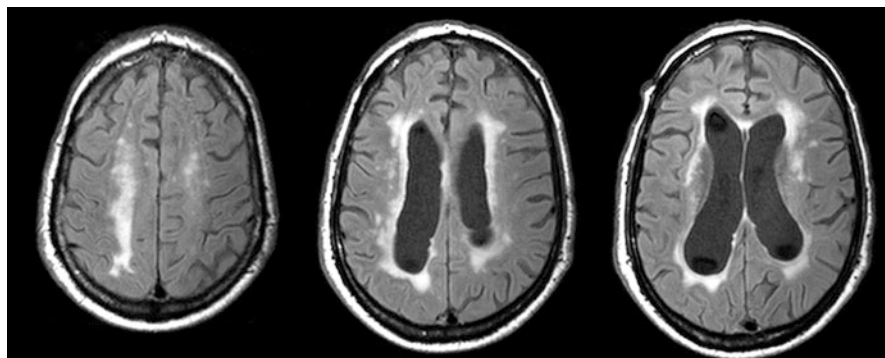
Fluid-attenuated inversion recovery (FLAIR) MRI of an elderly patient showing periventricular white matter hyperintensities due to cerebral small vessel disease
